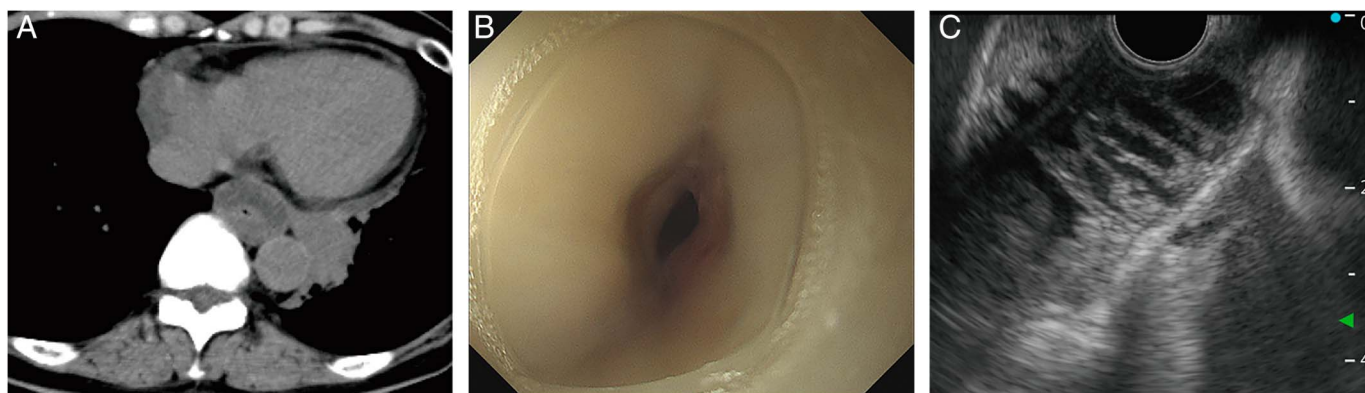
Computed tomography and endoscopic ultrasound images. (A) Computed tomography revealed circumferential and concentric wall thickening in the lower esophagus adjacent to the lung tumor. (B) The endoscopic view of the lower esophagus showing stenosis with apparently normal overlying mucosa. (C) Endoscopic ultrasound showed a submucosal cystic lesion measuring 30 mm in diameter with an irregular septum.
